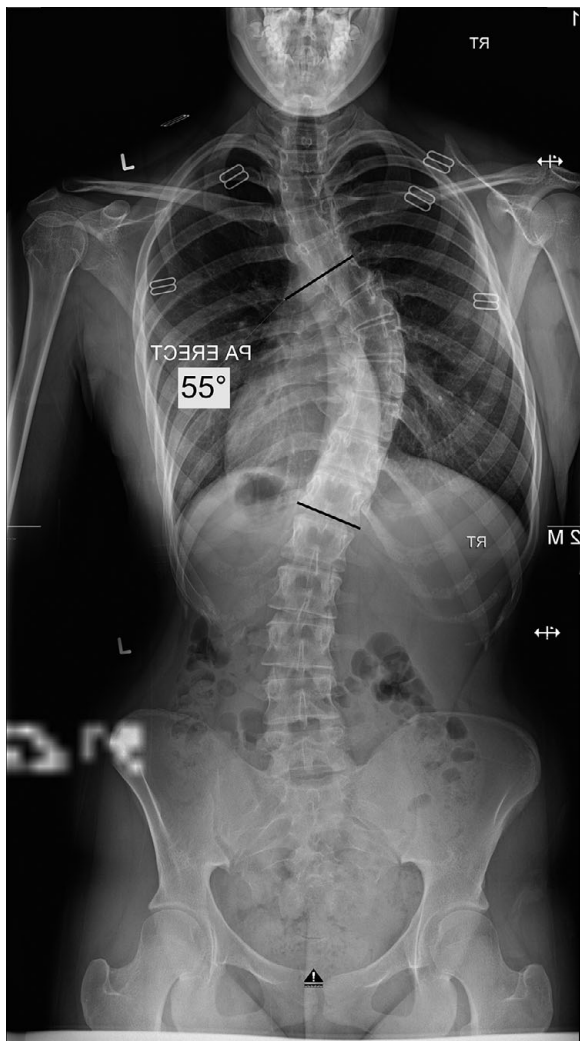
PA standing whole spine radiograph
